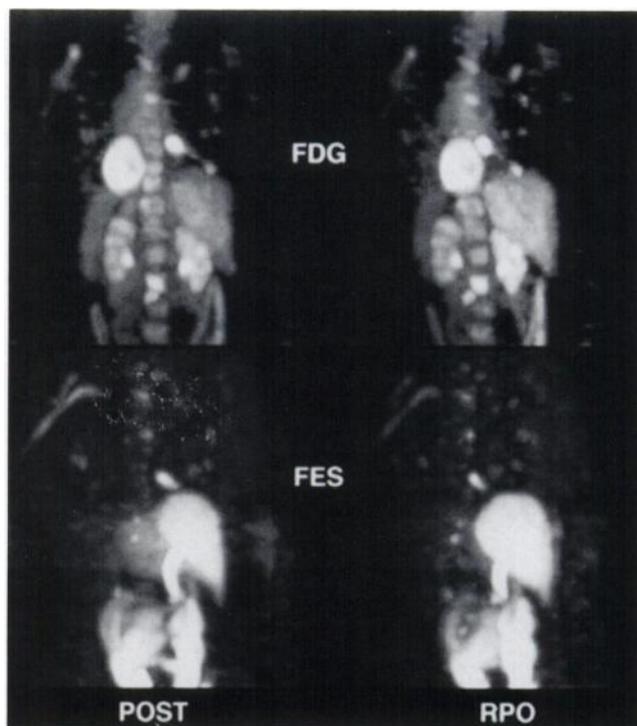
Anterior and right posterior oblique volume-rendered maximum-activity-reprojection FDG and FES images from a patient with breast cancer metastatic to bone demonstrate concordant localization of both tracers in this ER-positive tumor in innumerable skeletal metastatic foci, particularly in the vertebrae and ribs. Moderately intense FDG uptake in myocardium was visualized in this patient despite her fasting state. Renal excretion of FDG and hepatobiliary excretion of FES are demonstrated. The FES images also visualize activity along the course of proximal left arm veins consequent to tracer injection on this side.
